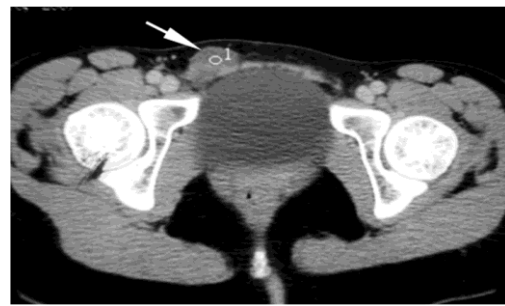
CT scan showing the globular cystic swelling in hernial sac
